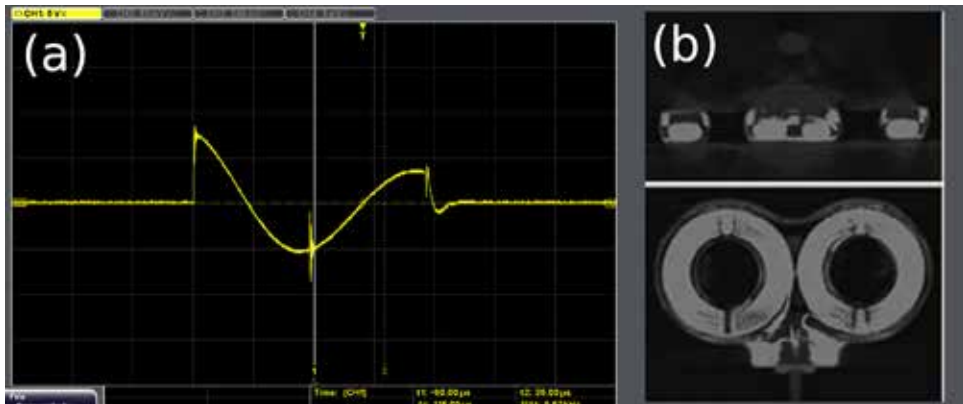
On the left (a) screen export from the oscilloscope device, plotting the induced voltage in a pick-up coil 3cm from coil surface iso-center using 17% TMS MO. On the right (b) the bottom and side-way X-ray scan
